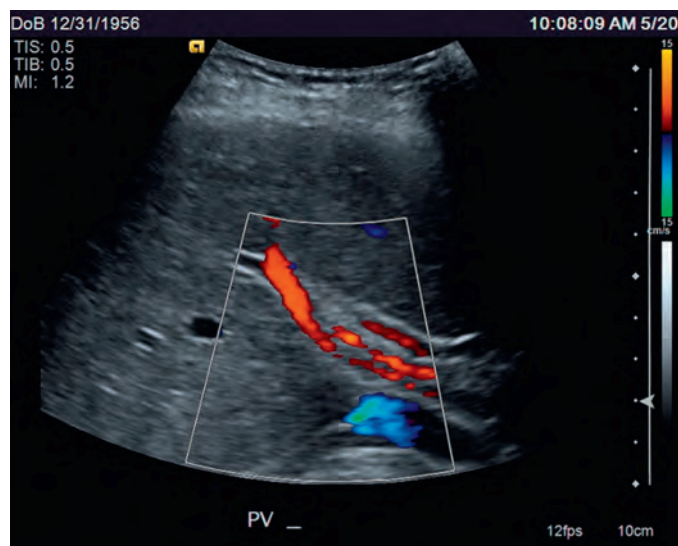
Portal vein thrombosis: sonographic findings.
